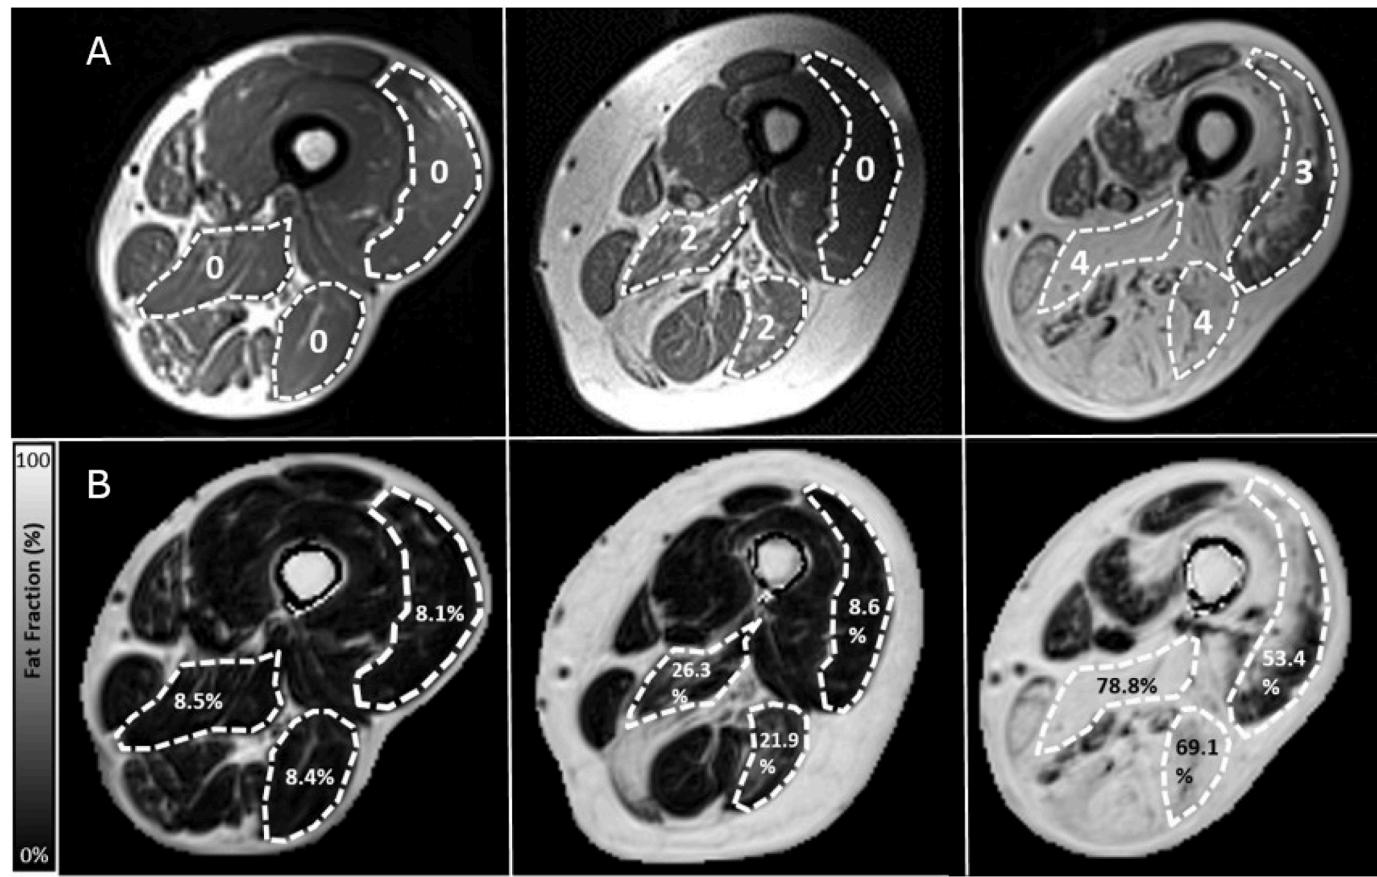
T1-weighted and Dixon images of the upper legs of three different FSHD patients.
